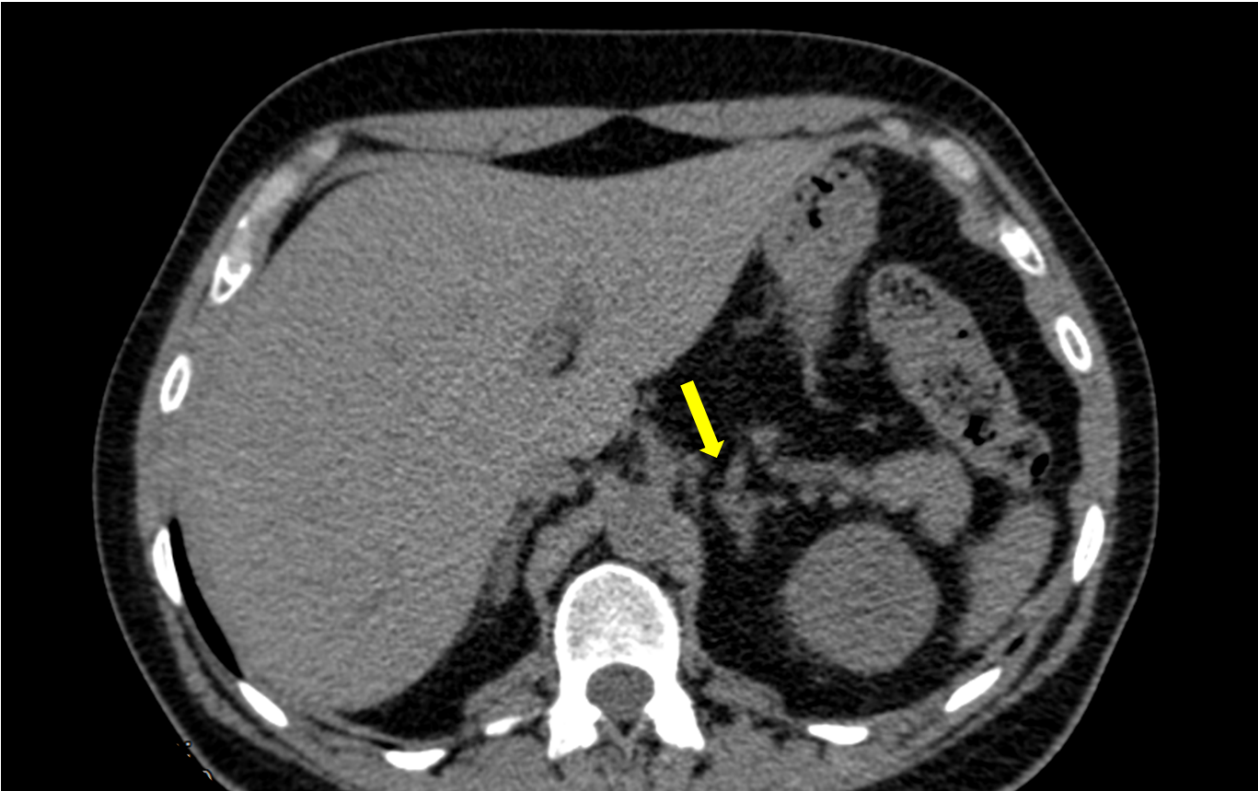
Pre-surgical abdominal CT scan of the patient, showing an enlarged and irregular left adrenal not suggestive of adenoma
